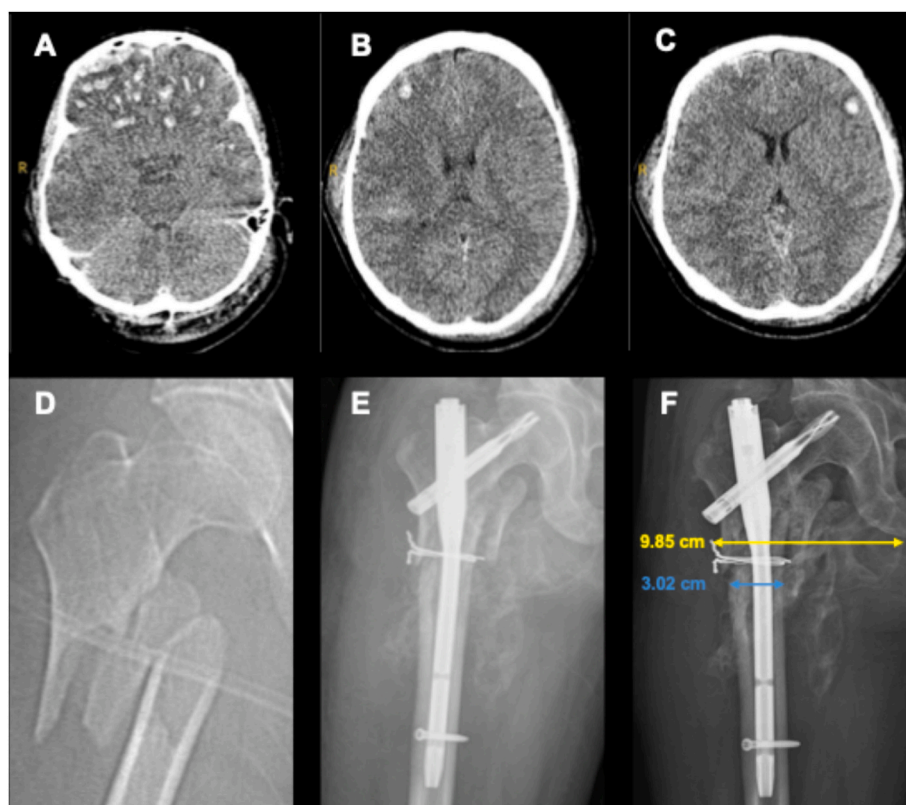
Representative case and callus index calculation. A 45-year-old male, an electric moped cyclist, sustained polytrauma with a traumatic brain injury (GCS = 9). Brain CT upon admission showed multiple brain contusions involving the bilateral frontal lobe, temporal lobe, and parietal lobe (A–C), along with a comminuted right femur fracture (D). The surgical notes indicated the observation of robust callus formation at 22 days after initial injury, and radiographs taken at 1 months (E) and 2 months (F) follow-up showed widest callus index of 3.26. Callus index is calculated by the widest diameter of the callus (yellow arrow) divided by the diameter of the bone at or adjacent to the fracture site (blue arrow).
